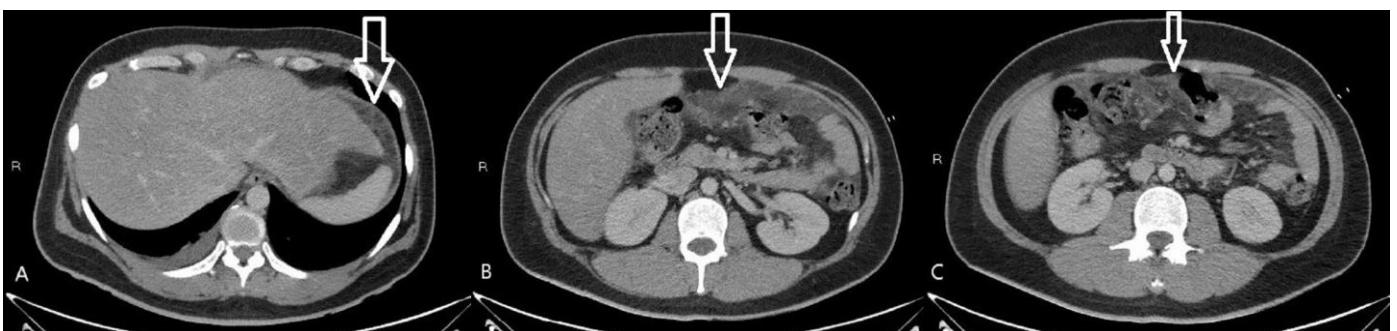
A 30-year-old gentleman with SPTCL, on a follow-up scan post initial, first round of chemotherapy regime. Contrast-enhanced computed tomography of the abdomen/pelvis.
